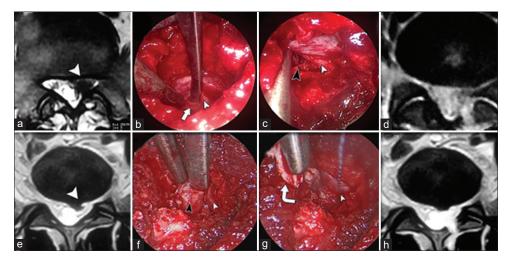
Same patient (a) pre-operative axial MRI showing left L5S1 herniated disc. (b) Intraoperative image with endoscope sheath position as shown in Figure 1d, the dissector is gently retracting the S1 root (white arrowhead) and passed underneath the remaining part of ligamentum flavum (white arrow). (c) Camera-lens complex in contralateral position [as shown in Figure 1e] showing full root path (white arrowhead) after annular incision and removal of the disc (black arrowhead). (d) Postoperative MRI is revealing adequate disc removal. Images are for another patient. (e) Axial MRI is showing L4-5 left herniated disc. (f) The L5 nerve root (white arrow) is retracted to reveal subradicular disc herniation (black arrow). (g) The nerve root (white arrow) is kept in retraction by cottonoid, followed by annulotomy and removal of the herniated disc by rongeur (curved white arrow). (h) Post-operative MRI is confirming the success of the procedure.
